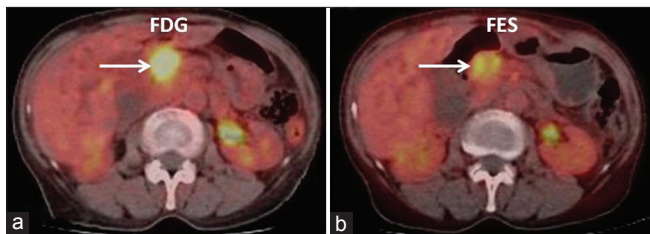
Fused axial ¹⁸F-fluorodeoxyglucose (a) and ¹⁸F-fluoroestradiol (b) positron emission tomography-computed tomography images showing periampullary lesion (arrow) with intrahepatic biliary dilatation. Findings suggest estrogen receptor expressing periampullary lesion likely breast metastasis in this case
